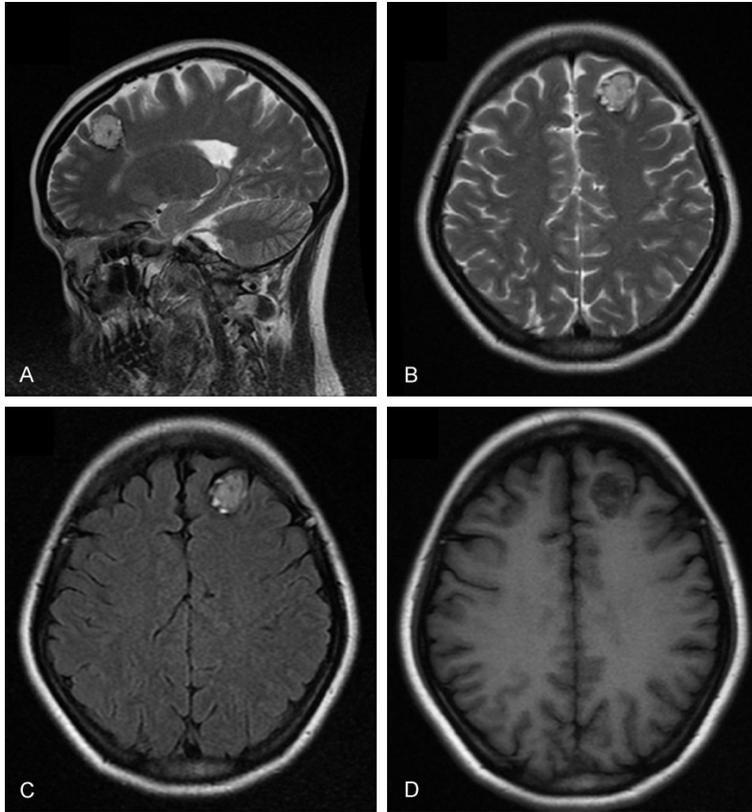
MRI findings on the pregnancy at the view of T2 sagittal plane (A), T2 coronary plane (B), T1 coronary plane (C) and diffuse weighing imaging coronary plane (D).
